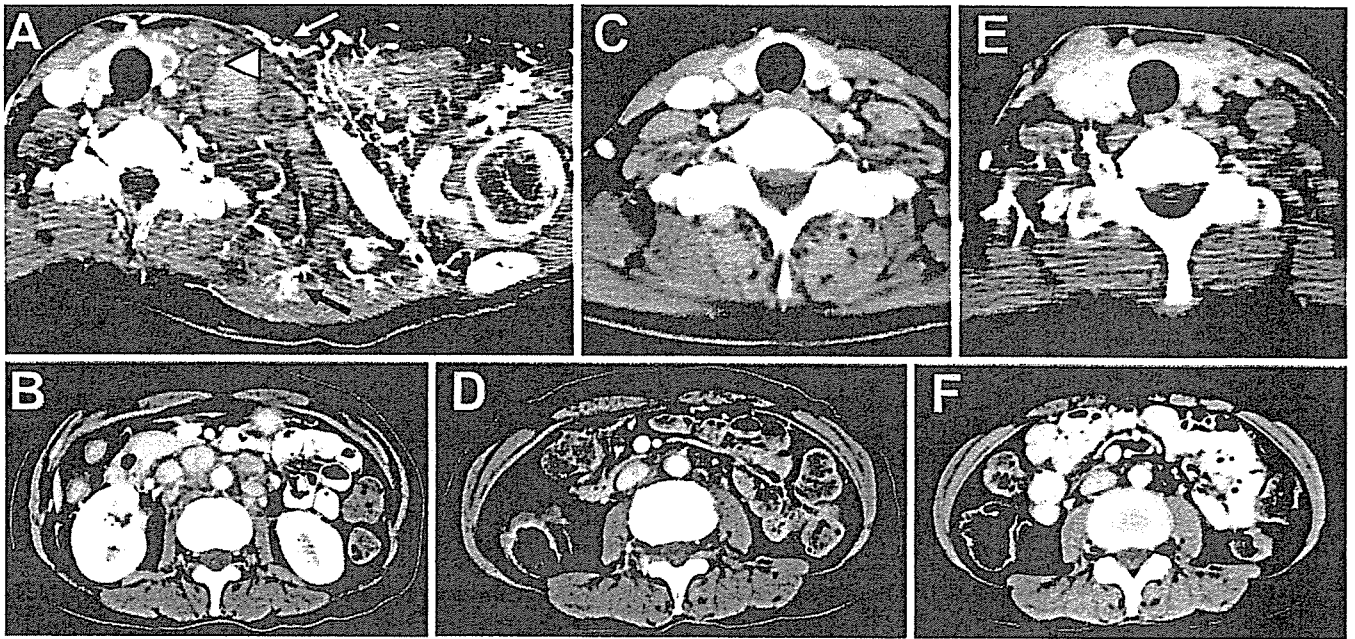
Neck and abdominal computed tomography scans at first diagnosis (A, B), one cycle after chemotherapy (C, D), and two cycles after chemotherapy (E, F). A Bulky swollen lymph nodes in the left supraclavicular portion with a complete obstruction of the left internal jugular vein (*arrowhead*)
